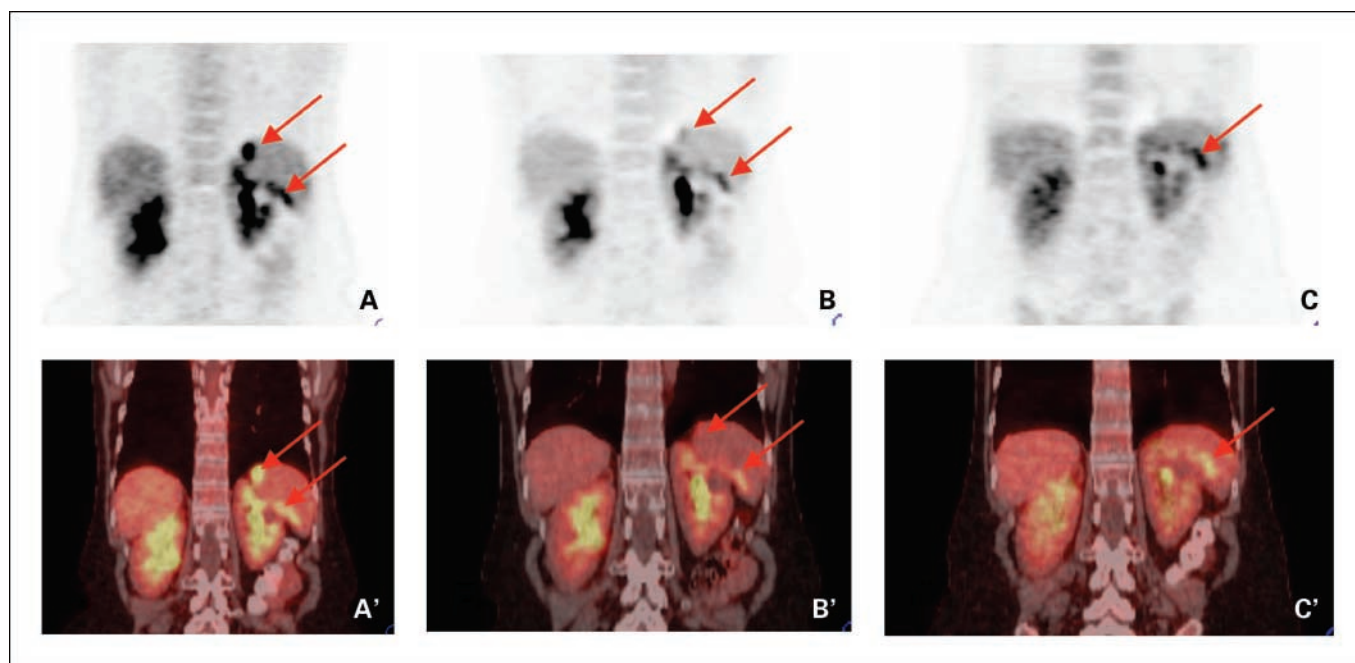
Positron emission tomography (*top*) and positron emission tomography-computed tomography (*bottom*) in a 53-year-old female with peritoneal mesothelioma before (*A* and *A'*), after first cycle (*B* and *B'*), and after second cycle (*C* and *C'*) of SS1P therapy. After first cycle, there was a decrease in the standard uptake values in the tumors on left anterior surface of liver and around the spleen. After the second cycle, there was no fluorodeoxyglucose uptake in the tumor on the left anterior surface of the liver.
